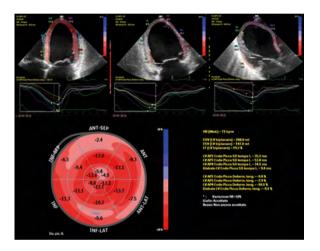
Echocardiography of an 18-year-old patient treated with isotretinoin admitted to the ED due to sudden pain in the left iliac fossa and exertional dyspnoea [17]
